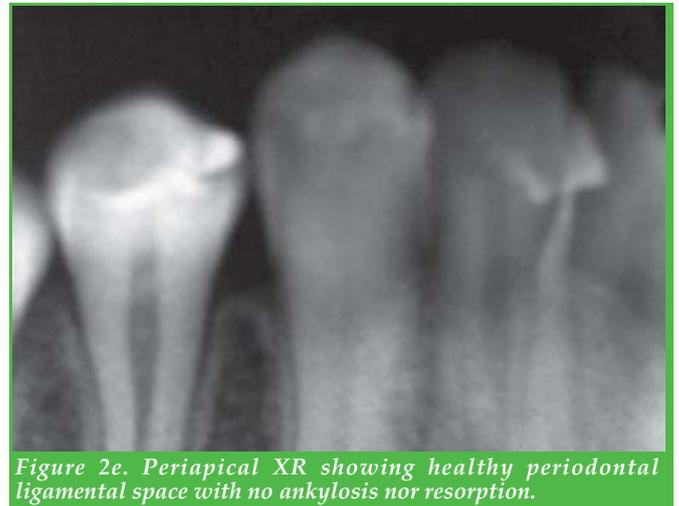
Periapical XR showing healthy periodontal ligamental space with no ankylosis nor resorption.
